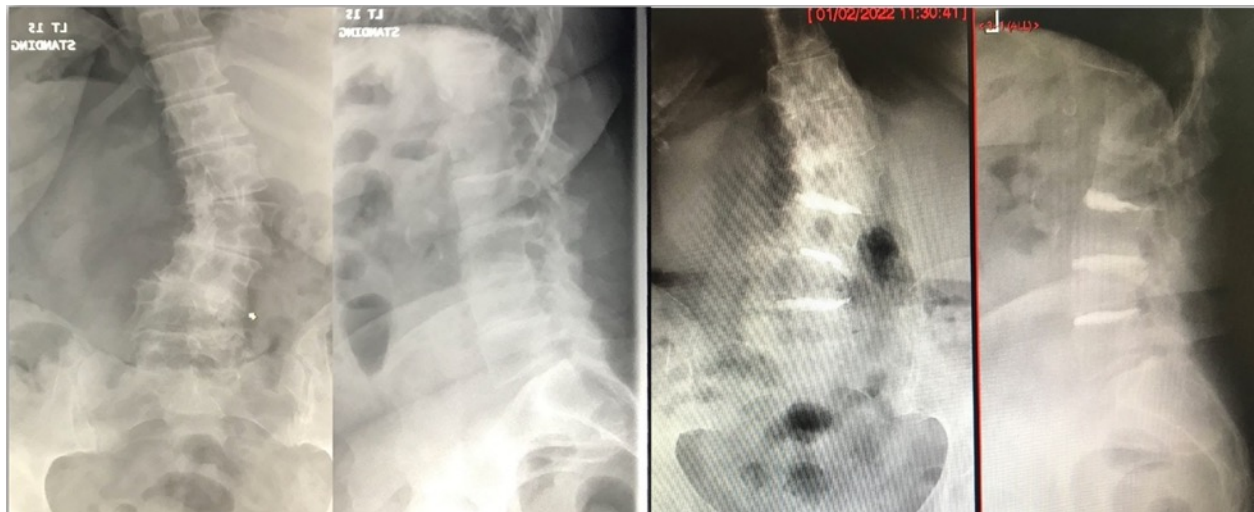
Cement Discoplasty for degenerative scoliosis. 78-year old lady with degenerative scoliosis, back pain 5/10 and leg pain (R L34 dermatome) 9/10. Had L34 extra-foraminal decompression and open CD, percutaneous CD at L23 and L45. No peri-operative or early complications. A & B: Pre-operative radiographs. C & D: Two-year post-operative radiographs with restoration of disc height at affected levels, stabilisation of the scoliosis. VAS was 3/10 and ODI was 22%.
